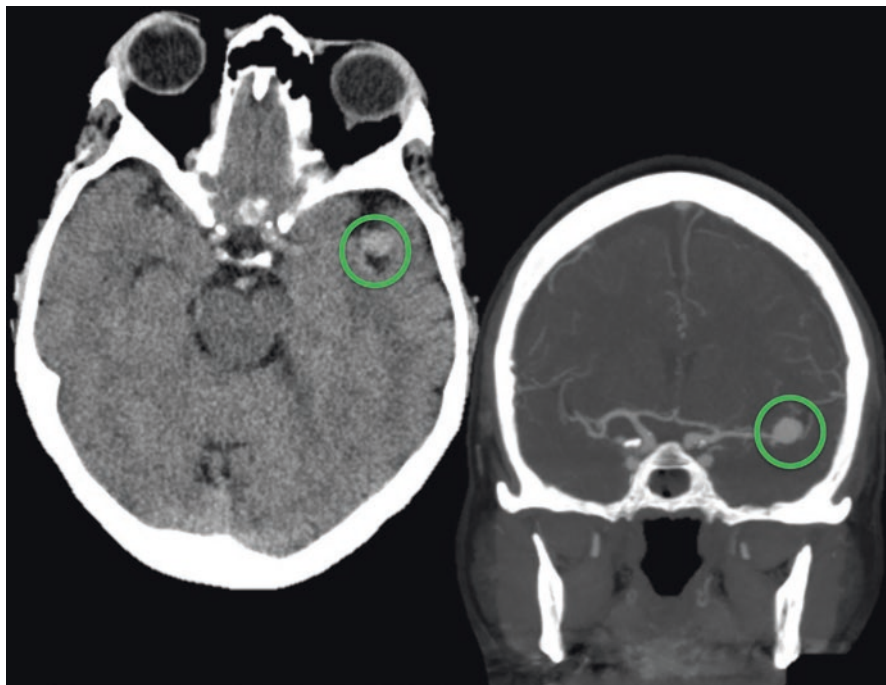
Left side image is an axial image of a non contrasted head CT. A hyperdensity is noted within the left sylvian fissure and is likely to be an aneurysm (*green circle*). Right side image is a coronal image of a CT angiogram of the head which clearly identifies a sizeable left middle cerebral artery aneurysm (*green circle*)
